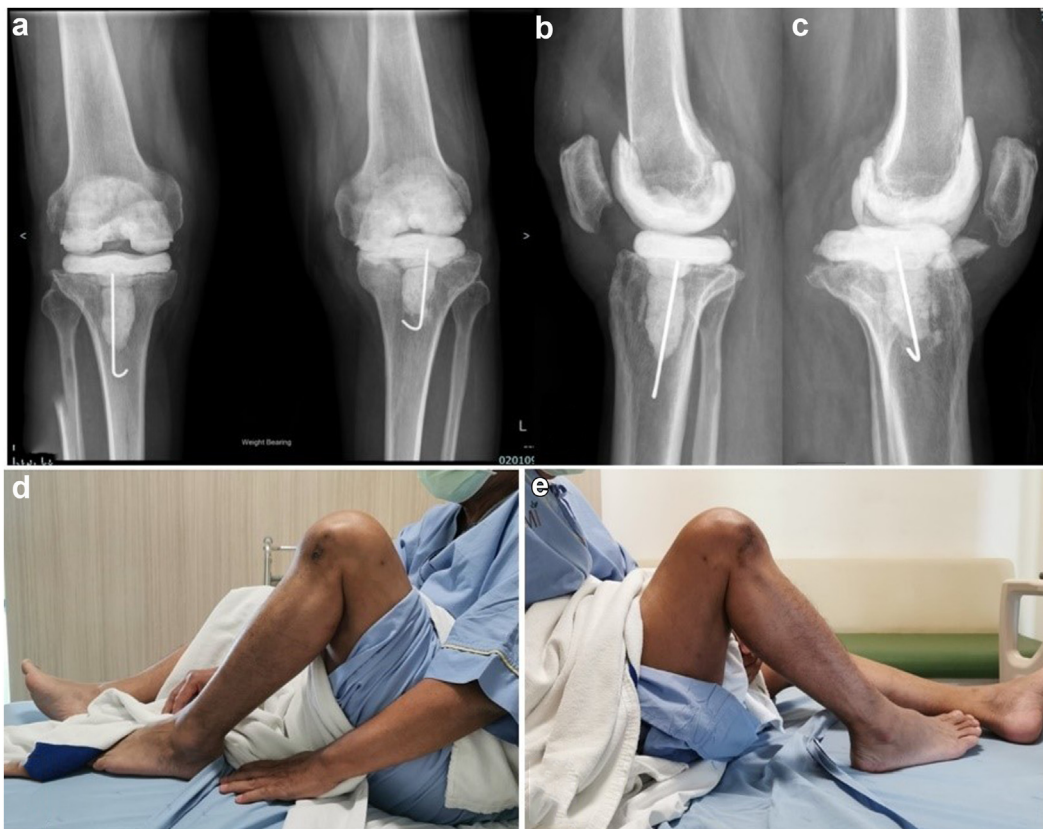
(a–c) Preoperative radiograph before reimplantation. No femoral spacer complications were observed in either knee. (c) Nevertheless, in the left knee, a minor rim fracture of the tibial spacer was present without causing significant knee instability. Flexion range of motion of the knee before reimplantation: (d) left knee, (e) right knee.
